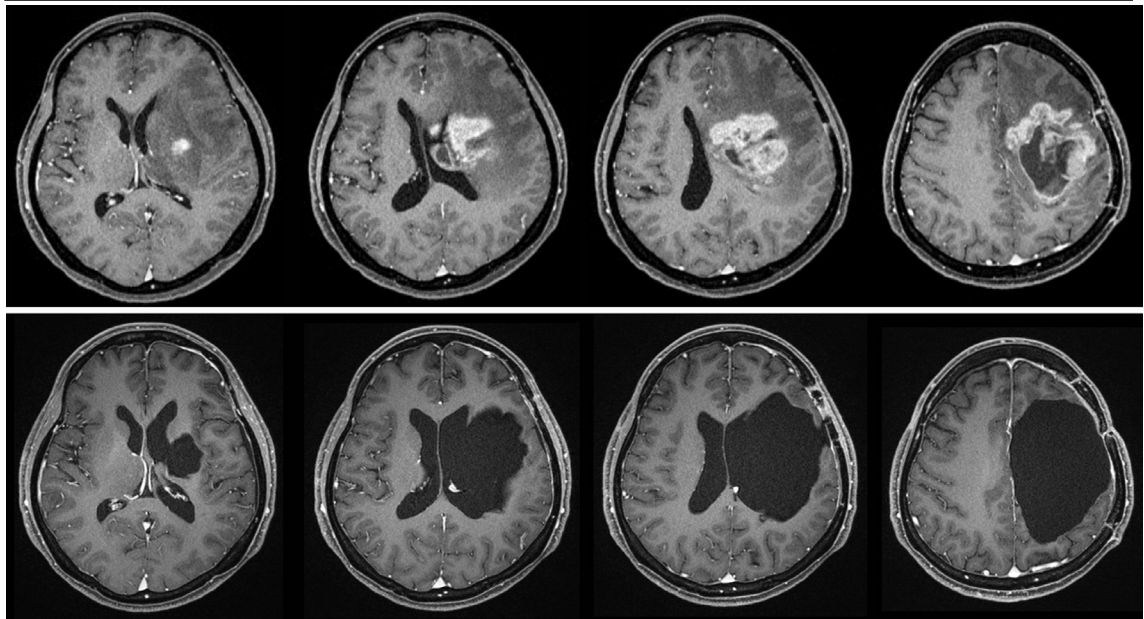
MRI before fifth operation revealing that the enhanced lesion invades to the basal ganglia, left lateral ventricle, splenium, and internal capsule (upper). Postoperative MRI revealing that the enhanced lesion totally disappears.
